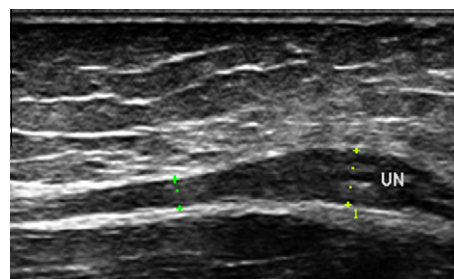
Ultrasound picture of an enlarged ulnar nerve just proximal to the medial epicondyl on a longitudinal section (diameter measured by calipers increases from 2.2 to 4.1 mm).
